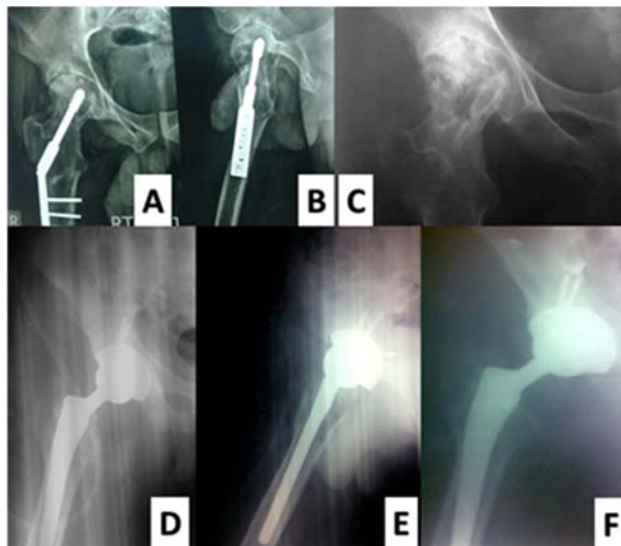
44 year's old female with right side hip arthritis and ankylosis due to posttraumatic arthritis: A & B) preoperative x-ray with DHS fixation; C) hip arthritis after removal of implant; D) postoperative x-ray with ceramic THA; E& F) x-ray 36 months postoperative.
